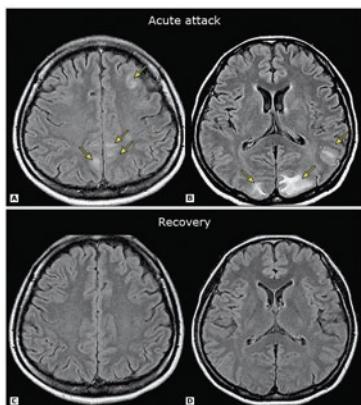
Brain MRI images showing posterior reversible encephalopathy syndrome in acute intermittent porphyria (AIP), in which central nervous system involvement may develop.
